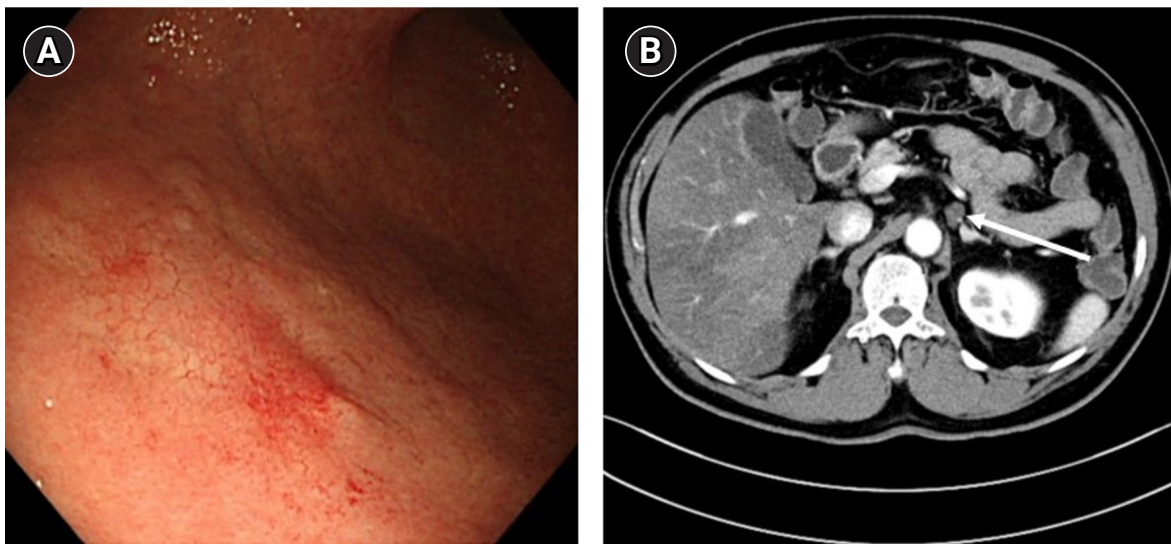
(A) Esophagogastroduodenoscopy diagnosed with early gastric cancer on lower body and greater curvature. (B) During pre-operative evaluation, left paraaortic lymph node enlargement was found just below splenic vein on computed tomography (arrow).
